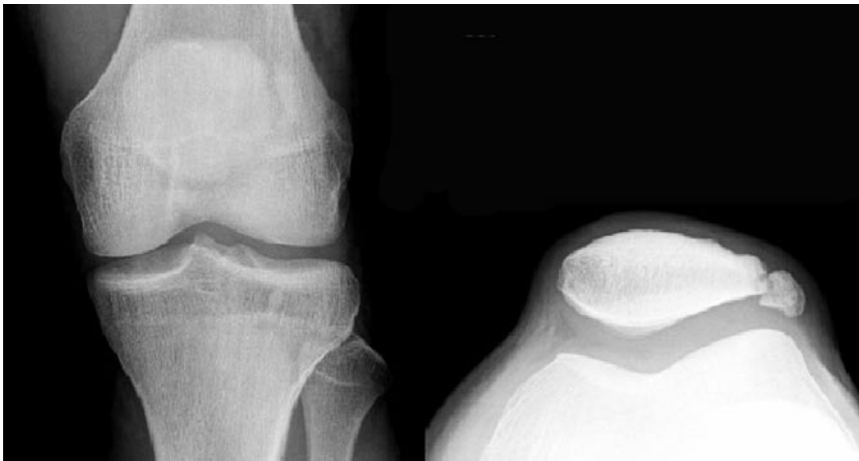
Preoperative radiographs reveal Saupé Type III bipartite patella.
